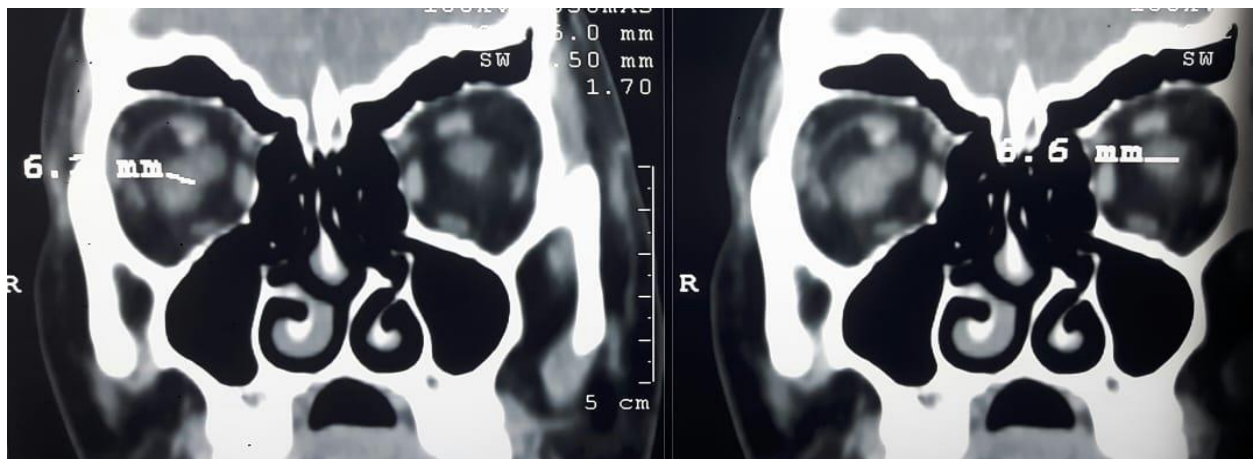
Coronal post contrast CT examination of the orbit revealed bilateral enlarged optic nerve sheath diameter measuring 6.7 mm to the right & 6.6 mm to the left
